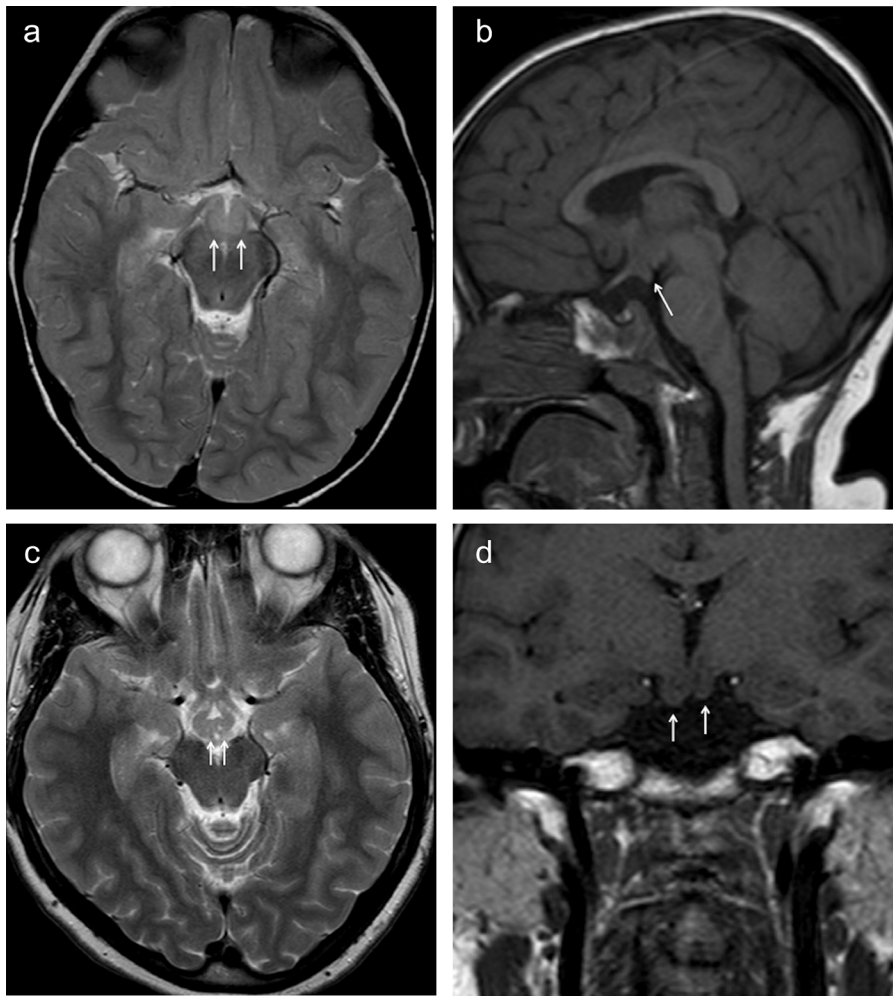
a-d. Axial T2-weighted image (a) of a 2-year-old male with XLD reveals thickened hypothalamus (arrows). Sagittal T1-weighted image (b) shows a 3-year-old male with hypothalamic enlargement (arrow). Axial T2-weighted image (c) of a 21-year-old female patient shows wrinkly hypothalamus (arrows); coronal T1-weighted image (d) of the same patient shows asymmetrical hypothalamic hamartoma-like enlargement (arrows).
